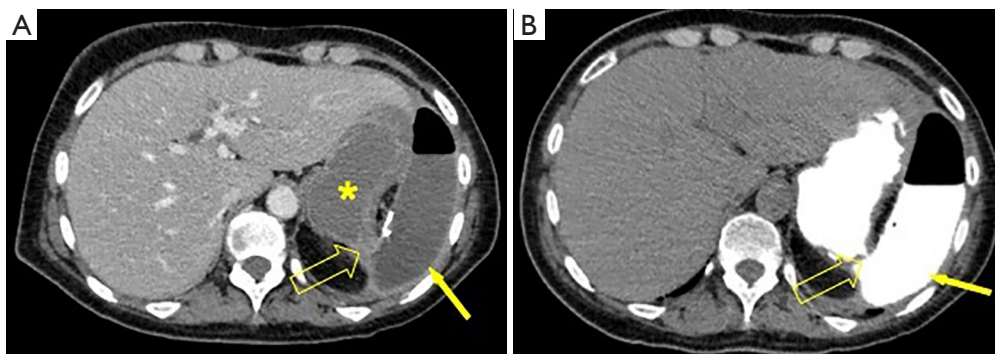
CT-scan imaging revealing the gastric perforation and abdominal spreading of contrast medium in case #1. (A) Sub-phrenic collection (filled arrow) with hydro-aerial level and focal attraction of the gastric wall (empty arrow). (B) Opacification of the collection after oral administration of Gastrografin® (filled arrow) and visualization of a thin through between gastric wall and collection (empty arrow) (24). *, stomach.
